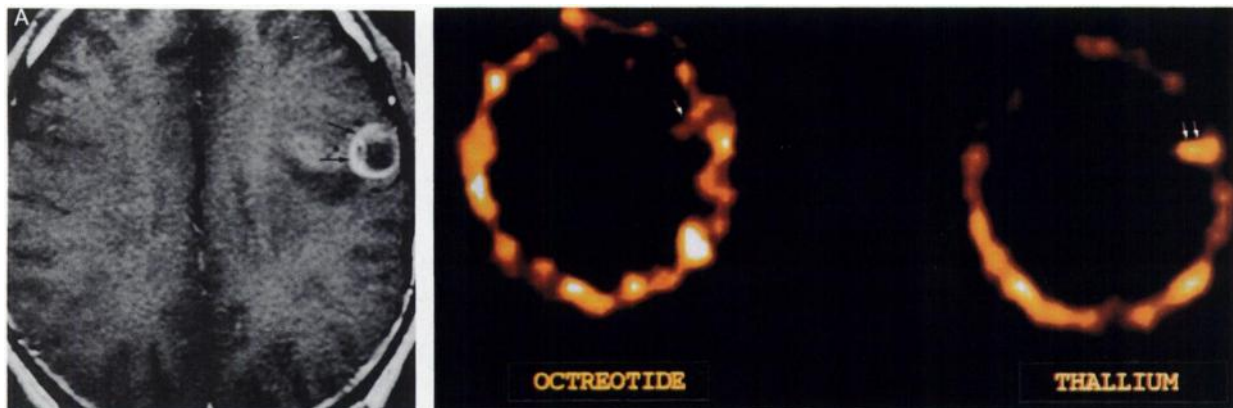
A 36-yr-old male with glioblastoma multiforme at left fronto-parietal region. (A) Gd-enhanced MRI shows ring enhancement of tumor mass (arrows) and low signal intensity, non-enhancing lesion at the infero-medial aspect of the tumor. (B) Both thallium and octreoscan show partial uptake of the radiotracers (arrows). The intensity of ^{111}In -pentetreotide is less than that of thallium.
